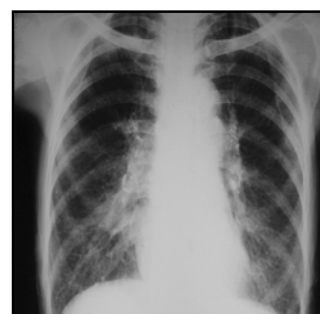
X-ray chest showing increased bronchopulmonary markings and opacities in the middle and lower zones of right lung.
